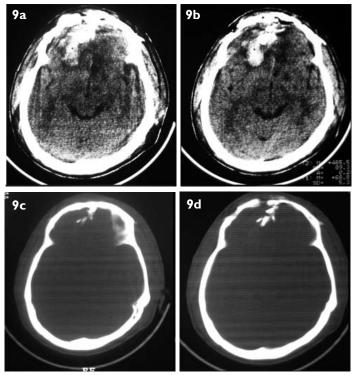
Postoperative follow-up axial CT images show a small contralateral frontal intracerebral haematoma and fracture of crista galli (further ipsilateral exploration would had been a disaster).
